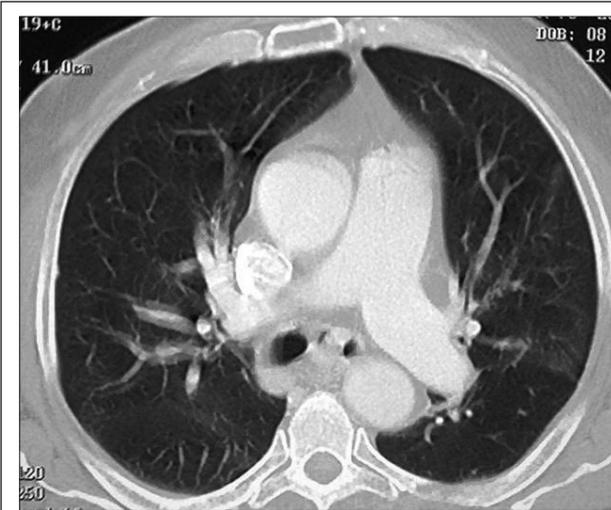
CT of the chest, showing an intraluminal mass in the left main bronchus.
